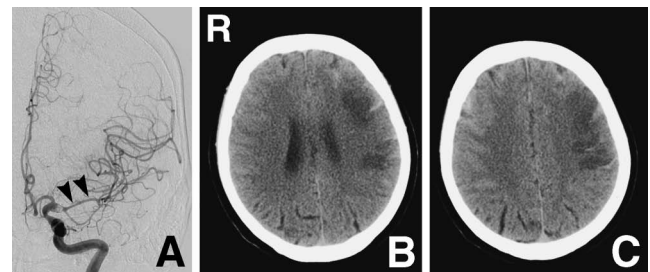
A: Left carotid angiogram, anteroposterior view, before arterial injection of 30 mg of fasudil hydrochloride on day 10 revealing delayed arterial spasm (arrowheads). B, C: Computed tomography scans on day 10 showing low density areas in the left frontal lobe.
